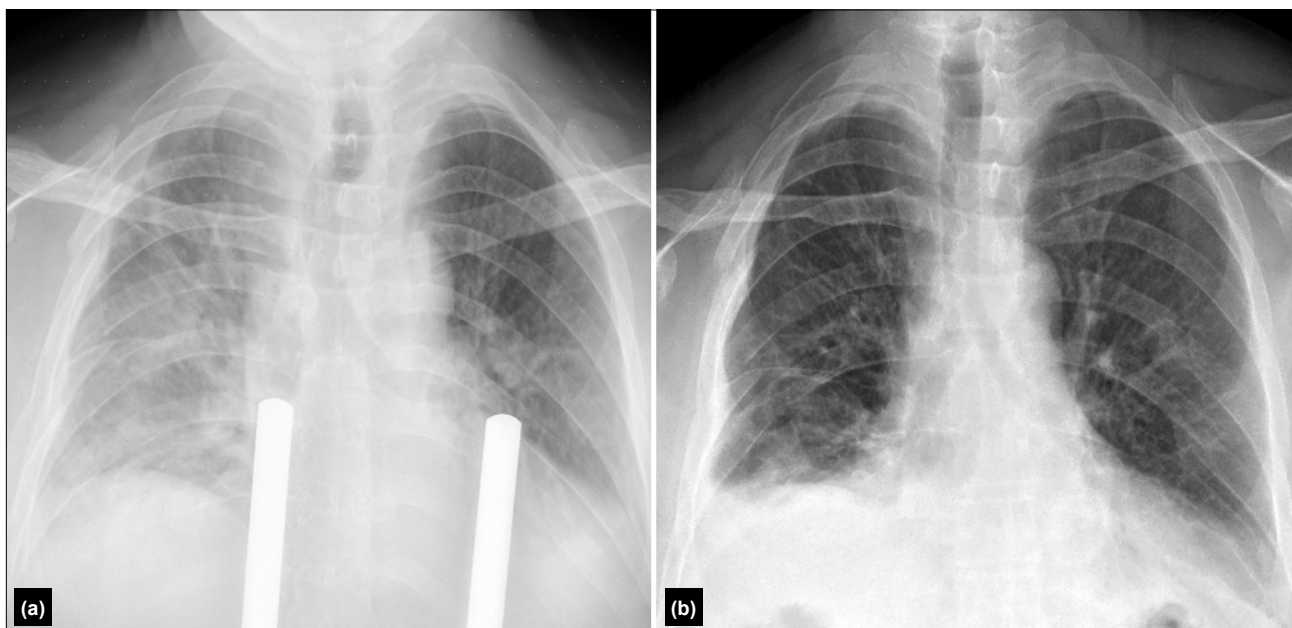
(a) Pre-procedural posteroanterior chest radiograph. (b) Post-procedural posteroanterior chest radiograph.
